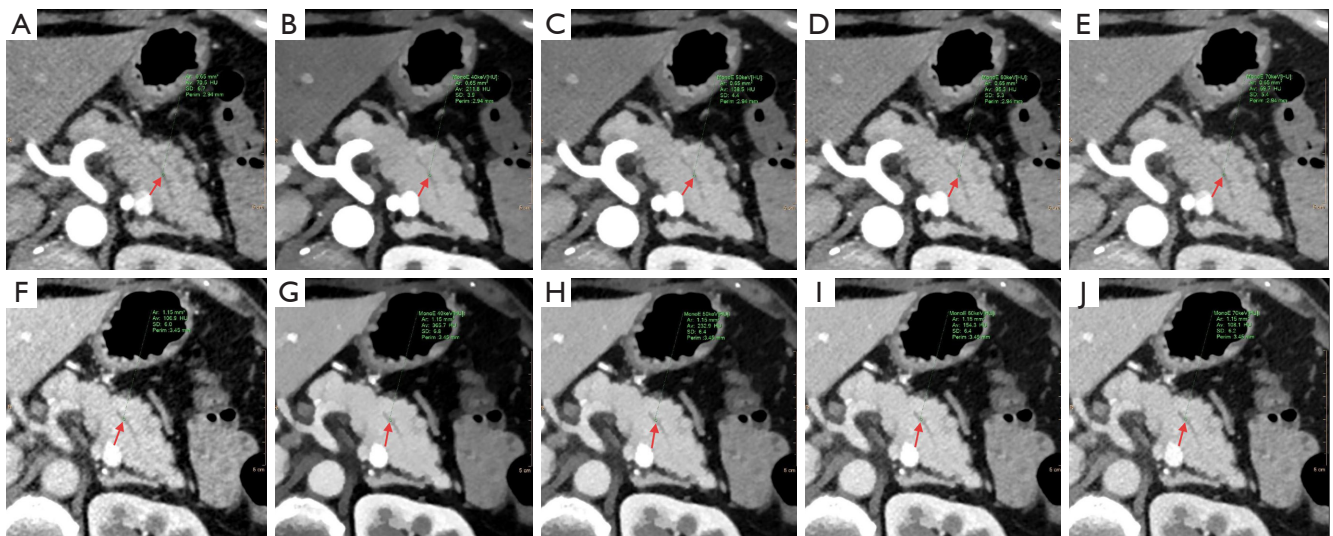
Axial CT images from a 56-year-old female with pathologically confirmed IPMN visually depict nondilated pancreatic ducts (indicated by the red arrow), despite inaccurate HU measurements. (A-E) PEI and VMI 40–70 during the arterial phase. Panel (F-J) PEI and VMI 40–70 during the portal venous phase. CT, computed tomography; HU, Hounsfield unit; IPMN, intraductal papillary mucinous neoplasm; PEI, polyenergetic images; VMI, virtual monoenergetic image.
